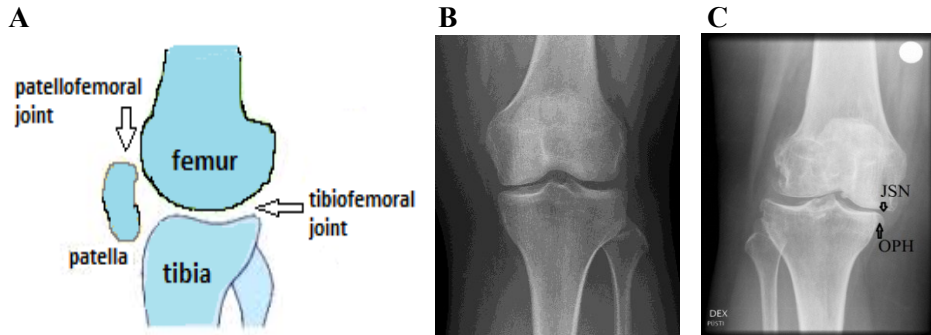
The structure of knee joints and their radiographic imaging. A) The knee joint is composed of three functional compartments: the medial and lateral tibiofemoral compartment and patellofemoral compartment. B) X-ray radiographs of the knee (no radiographic OA features). C) Radiographic knee OA—presence of osteophytes (OPH) and narrowing of joint space (JSN) in the knee joint (courtesy of Department of Radiology of Tartu University Hospital).
